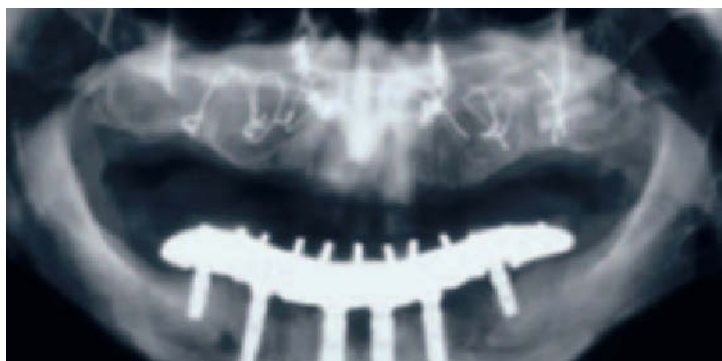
Panoramic radiograph after grafting procedure.
